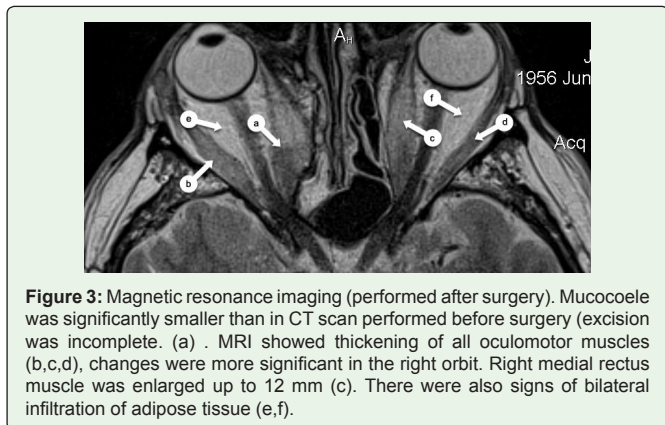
Magnetic resonance imaging (performed after surgery). Mucocoele was significantly smaller than in CT scan performed before surgery (excision was incomplete. (a) . MRI showed thickening of all oculomotor muscles (b,c,d), changes were more significant in the right orbit. Right medial rectus muscle was enlarged up to 12 mm (c). There were also signs of bilateral infiltration of adipose tissue (e,f).
